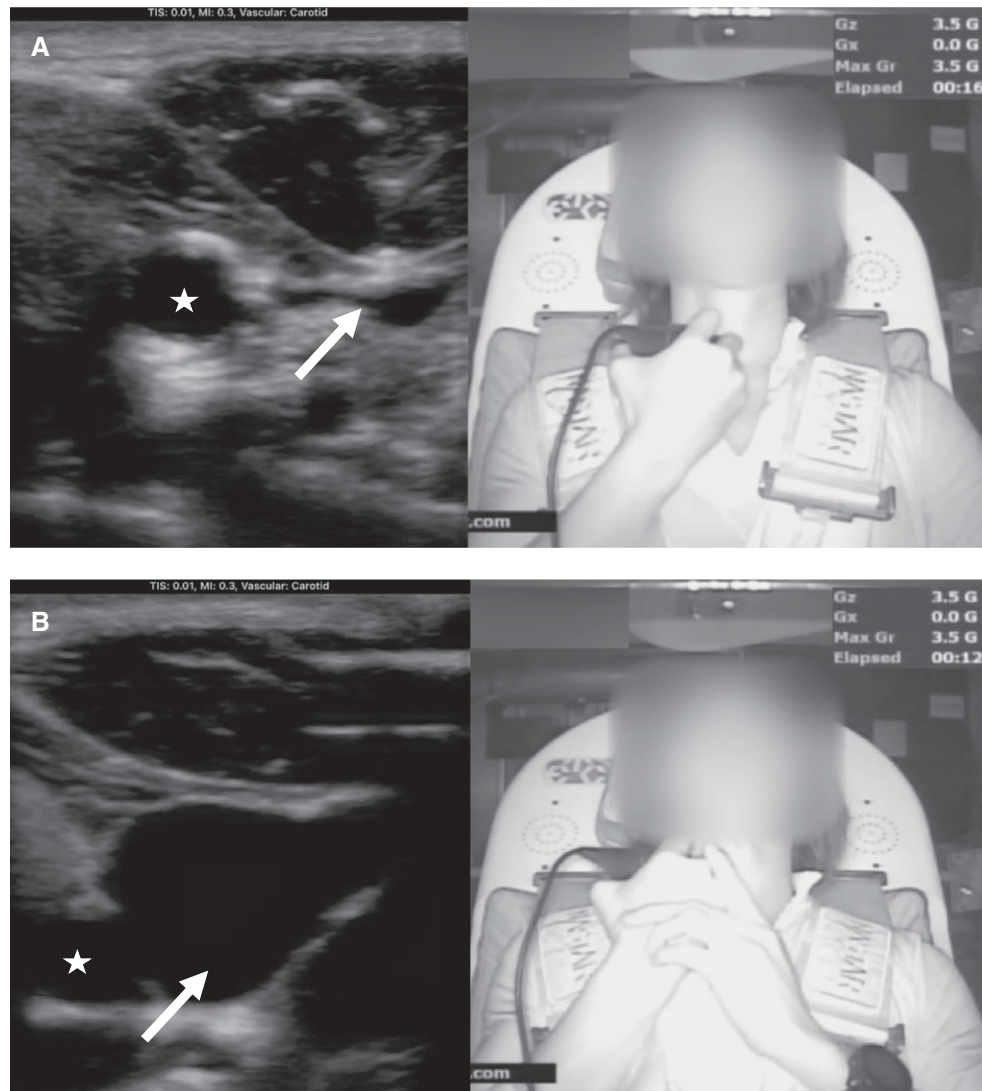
Jugular imaging by minimally experienced sonographer (Subject 2). A) Jugular vein as imaged by a minimally experienced sonographer while relaxed at +3.5 G_z. B) Jugular venous distention as imaged by a minimally experienced sonographer performing an anti-G straining maneuver at +3.5 G_z. The carotid artery is marked by a star; the jugular vein is indicated by a white arrow.
